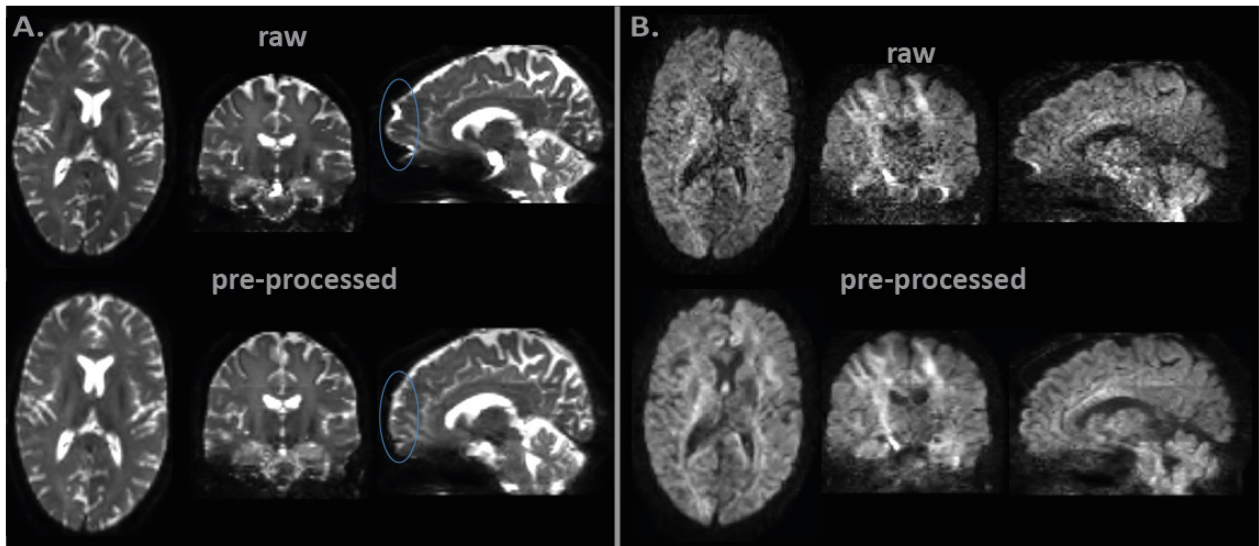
Raw and pre-processed images of a DWI volume. A) b_0 DWI volume. The geometric distortions are clearly improved as seen in the blue circles. B) b_1 DWI volume. The SNR is clearly improved.
